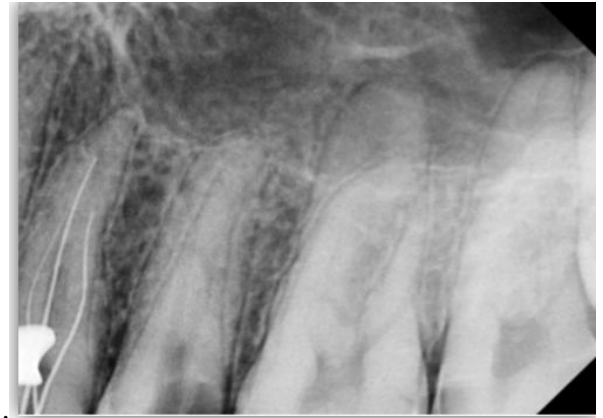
Establishing working length and confirmed by radiograph
